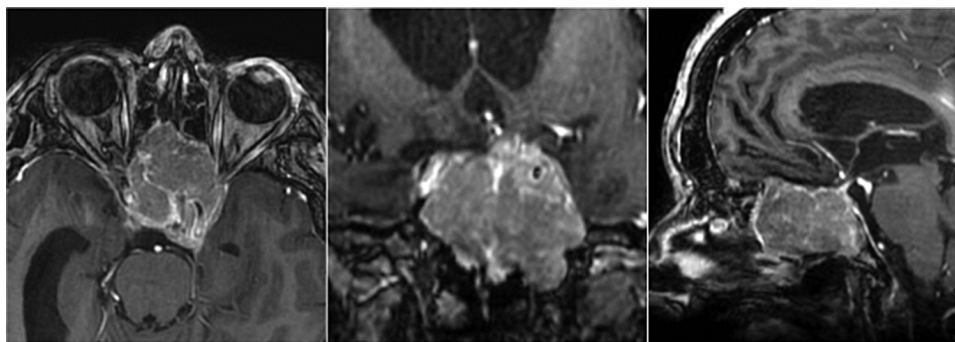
Axial (left), coronal (center), and sagittal (right) T1-weighted MRI scans with gadolinium enhancement showing invasive skull base recurrence of a *SMO*-mutant olfactory groove meningioma previously operated on 3 times and treated with radiotherapy in a 45-year-old woman. Both optic canals and pituitary gland and both carotid arteries are invaded and the patient suffers from pituitary dysfunction and blindness.
